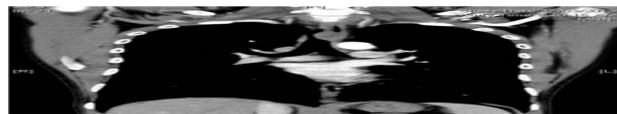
CT Thorax-Mediastinal window sagittal view showing mass in the distal trachea with luminal narrowing.
